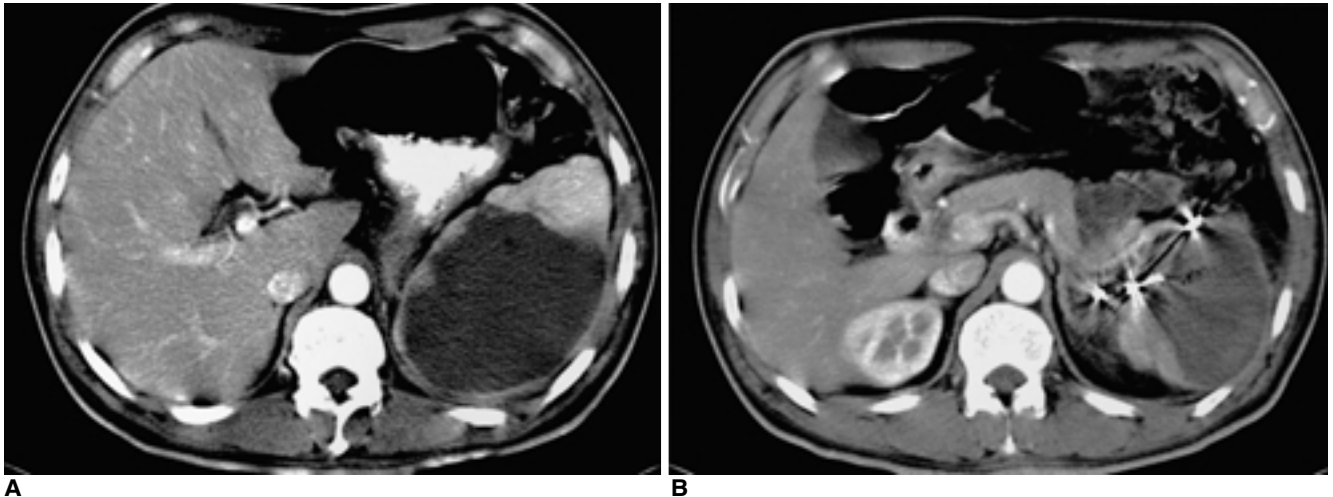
A, B. Post-embolization CT scan shows successful embolization of pseudoaneurysm but as a result, large infarcts are developed and only small portion in the spleen is normally preserved.
